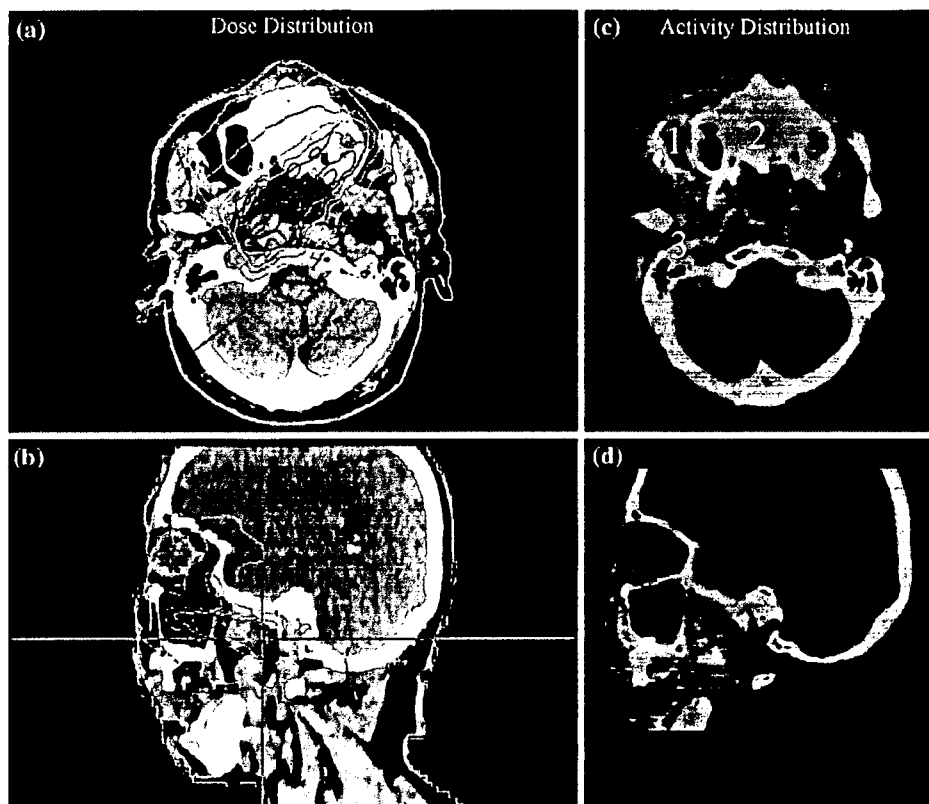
Dose distribution calculated with the proton treatment planning system and activity measured with the PET-CT apparatus on CT image after proton treatment of tumor in the head and neck. The iso-dose line of 100% is red, 80% yellow green, 50% light blue, and 20% purple. The activity line of 5 kBq/cc is red, 3 kBq/cc green, and 1 kBq/cc blue. Proton beam irradiation was performed with an SOBP of 70 mm, gantry angle of 330°, and dose of 2.0 GyE after irradiation with an SOBP of 80 mm, gantry angle of 230°, and dose of 2.0 GyE. The dose distributions on each CT image in axial and coronal planes are shown in figures (a) and (b), and the activity are shown in figures (c) and (d)
